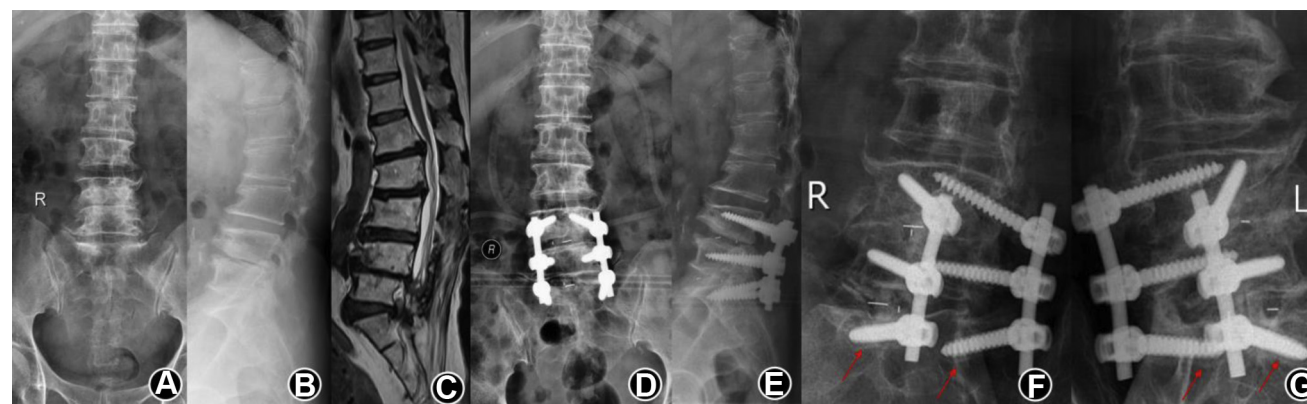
Female, 70-years-old, $T = -2.8$ SD (A, B). Preoperative X-rays showed degenerative changes of lumbar spine and kyphotic deformity in thoracolumbar spine (C). Preoperative MRI showed stenosis in L4-S1 (D, E). The lumbar anterior-posterior radiographs after surgery showed well
